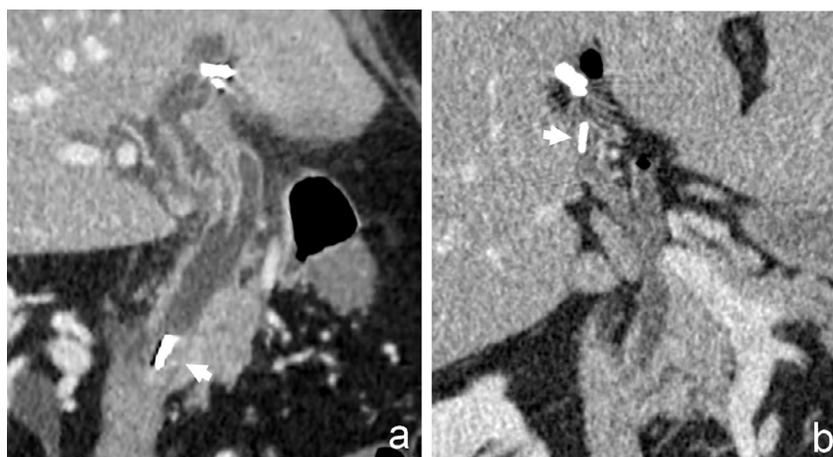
(a) CT scan revealed an occluding hyperdense material in the lower common bile duct secondary to postcholecystectomy clip migration (*white arrow*). (b) CT scan (2 years earlier) showed metal clips correctly positioned on cystic duct (*white arrow*) and cystic artery.
